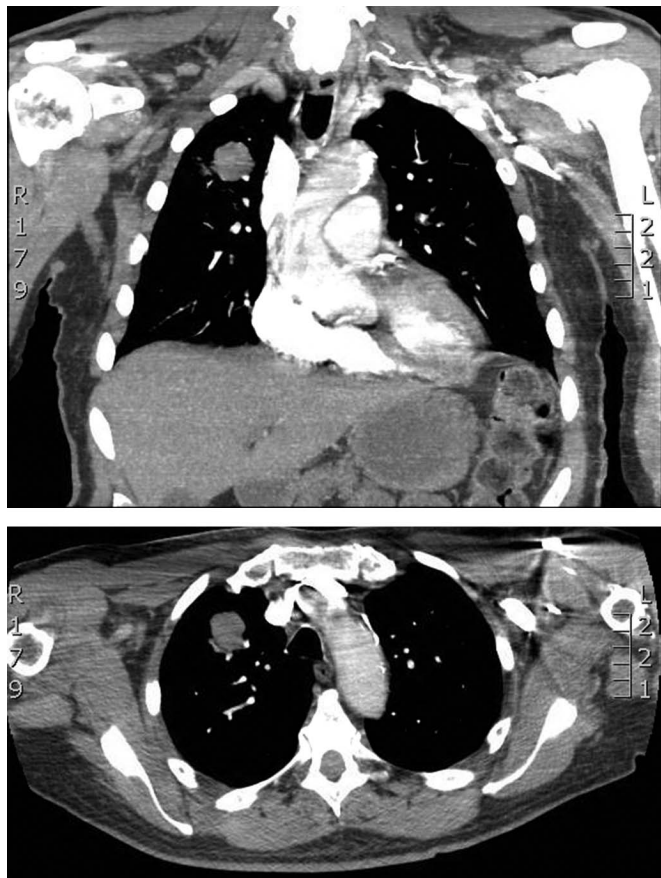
Computed tomography chest with 3-cm soft-tissue density in the anterior segment of the right upper lobe.
